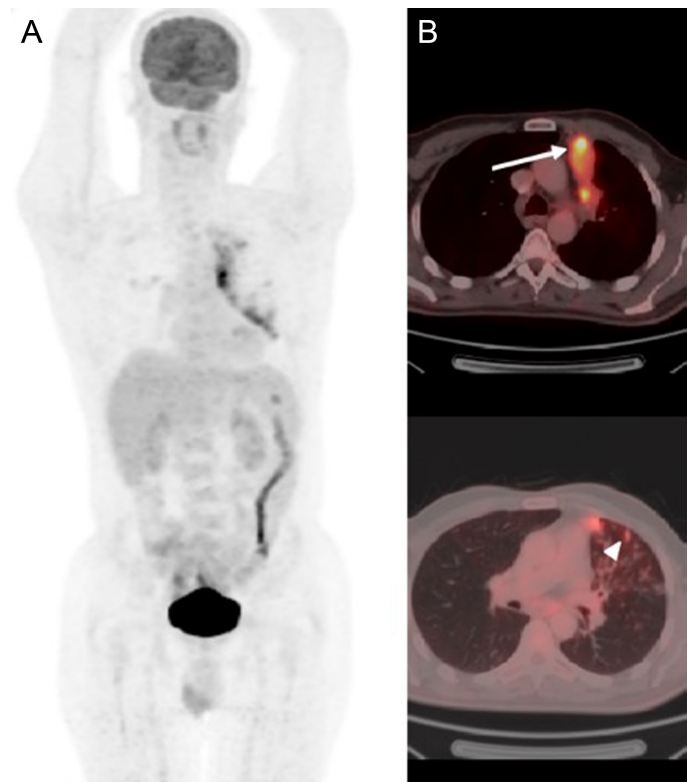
18-F FDG PET/CT scan showing pulmonary TB in a 51-year-old male patient. Whole-body maximum intensity projection images are shown (A). Trans-axial fused images showing FDG-avid consolidation (B; arrow), and reticulonodular opacities (B; arrowhead). CT, computed tomography; 18-F FDG, fluoro-2-d eoxy-D-glucose; FDG, fluorodeoxyglucose; PET, positron emission tomography; TB, tuberculosis.
